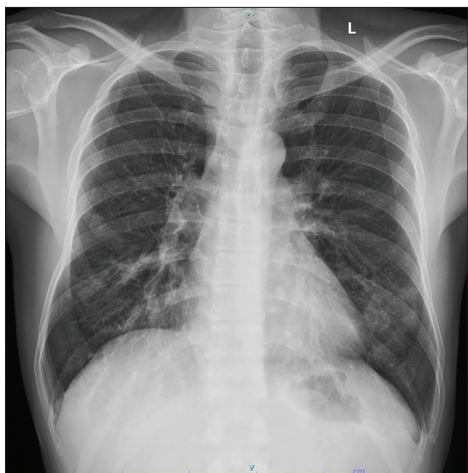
Chest X-ray posteroanterior view on admission showing ill-defined nonhomogenous opacities involving bilateral lower zones
